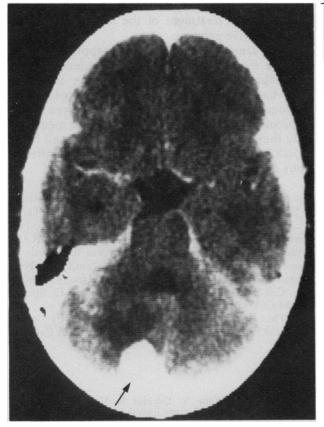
CT scan of head of patient IV-27, showing enhanced image of lesion in right posterior cerebellar hemisphere.
